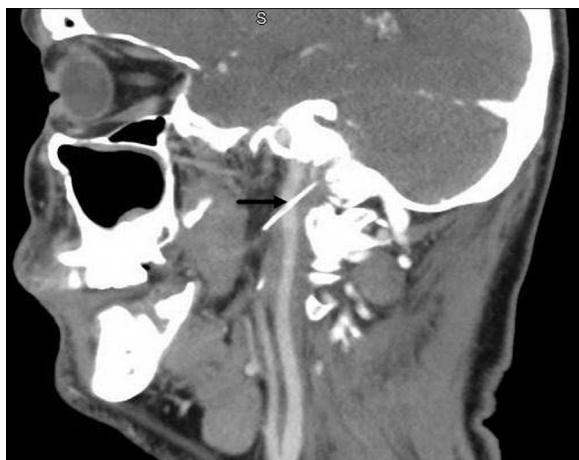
Sagittal contrast material-enhanced computed tomographic scan showing the broken needle fragment (arrow) located within the right internal carotid artery. The contrast material highlights the internal carotid artery.
